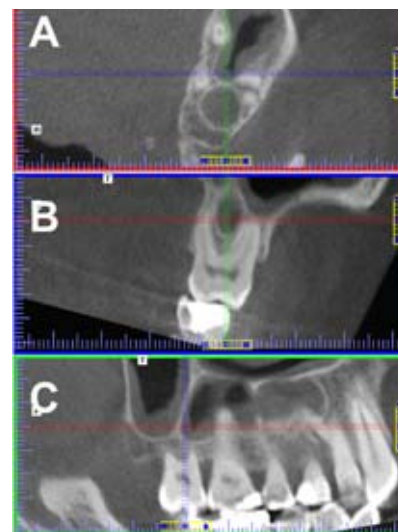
A,B,C = axial, coronal and sagittal CBCT images regio 17. A septum in the maxillary sinus (Underwood septum) extends between the buccal roots and the palatal root.
